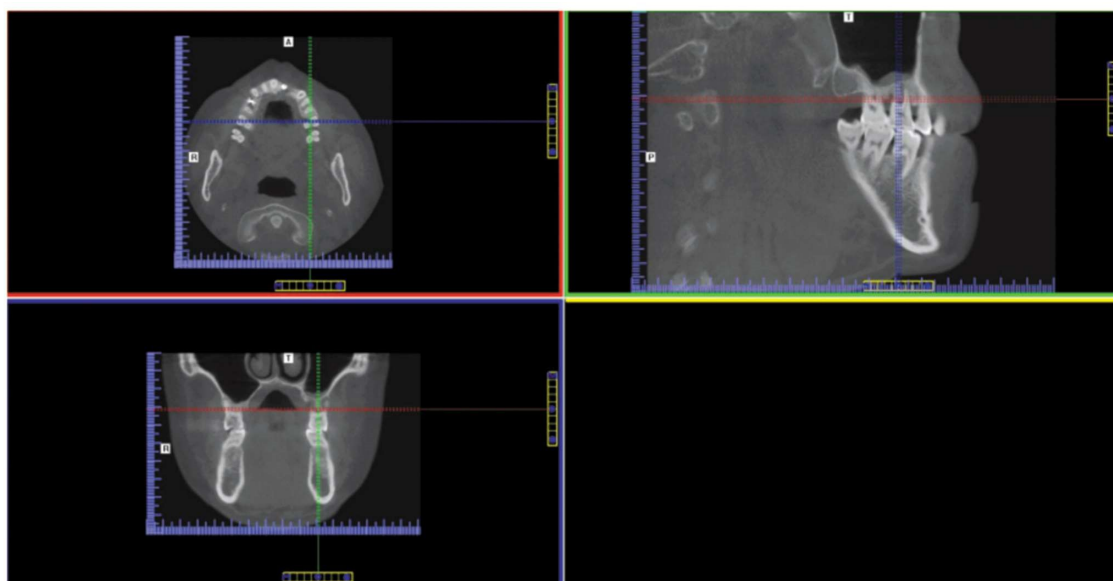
No.3 患者的左上第一磨牙术前 CBCT 影像
